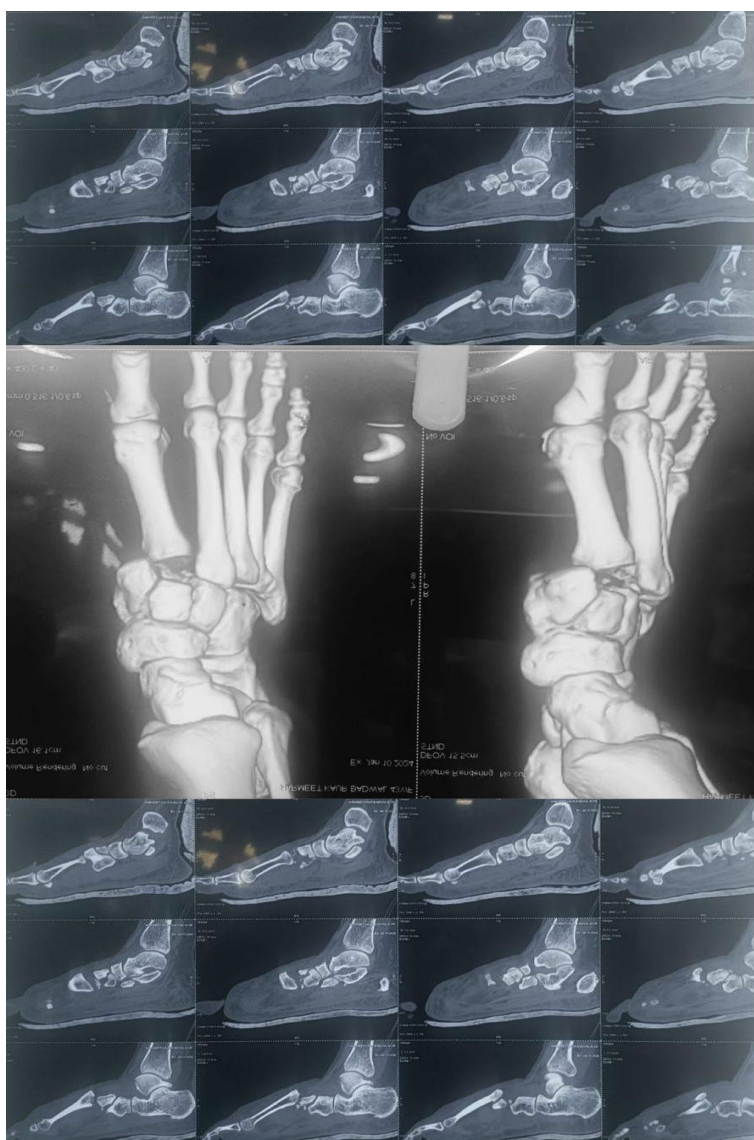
Case 2: CT scan Showing the Extent of the Fracture and 3D Reconstructions.
